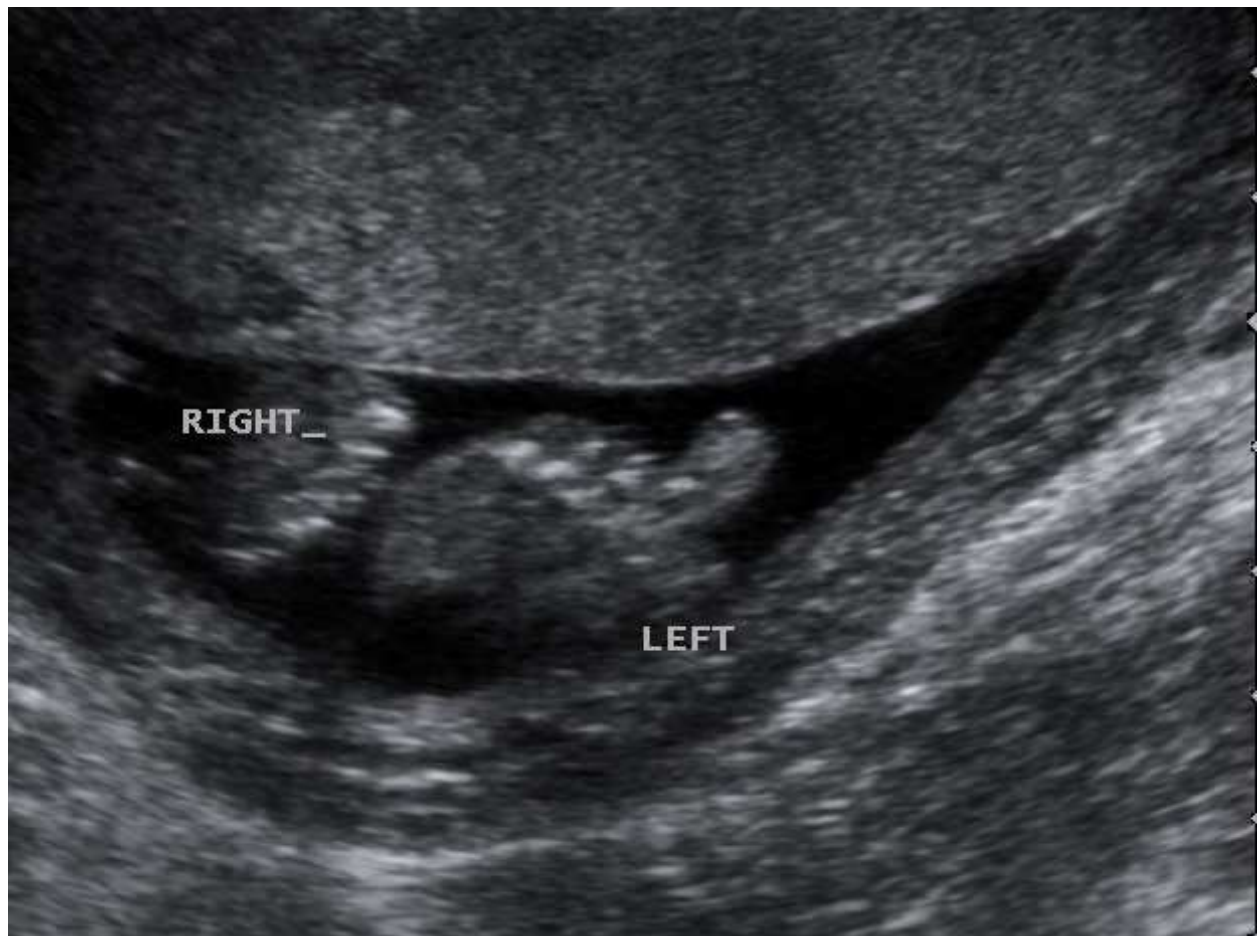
Ultrasonographic scan of the fetus at 24 gestational weeks demonstrating the difference in size between two second toes. Macrodactyly of the left second toe is confirmed by comparable measurements. This is another image of the same case presented in 'Prenatal diagnosis of isolated macrodactyly' in *Ultrasound in Obstetrics and Gynecology* 2009; 33: 360-362.
